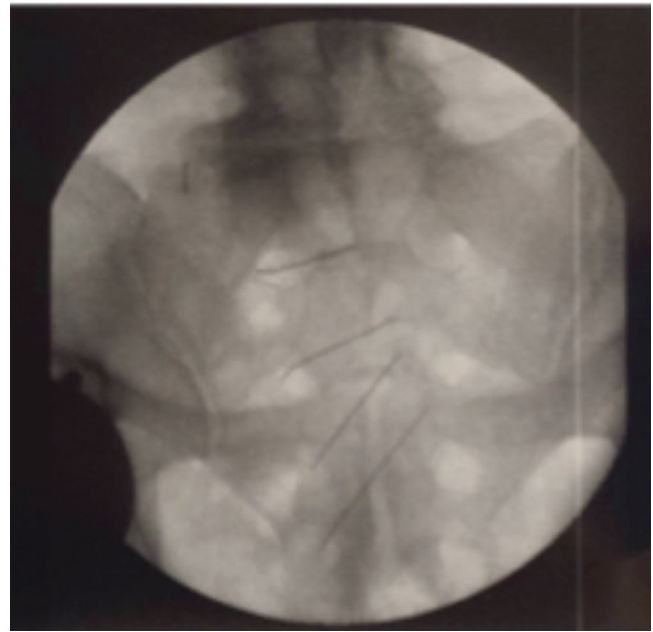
AP plain film projection. Radiofrequency probes (with 10 mm tips) are oriented across the S1–S4 dorsal foramina (medial to lateral)
